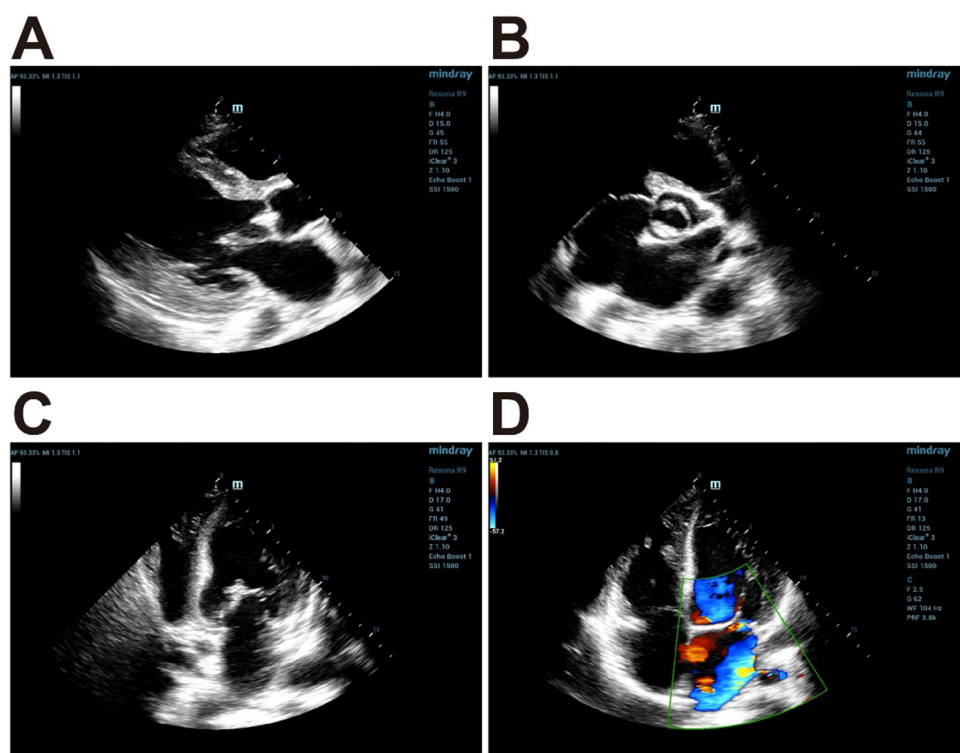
The results of transthoracic echocardiography at admission. A Aortic vegetation. B Bicuspid aortic valve malformation. C Mitral valve vegetation with prolapsed anterior mitral valve. D Severe mitral regurgitation
